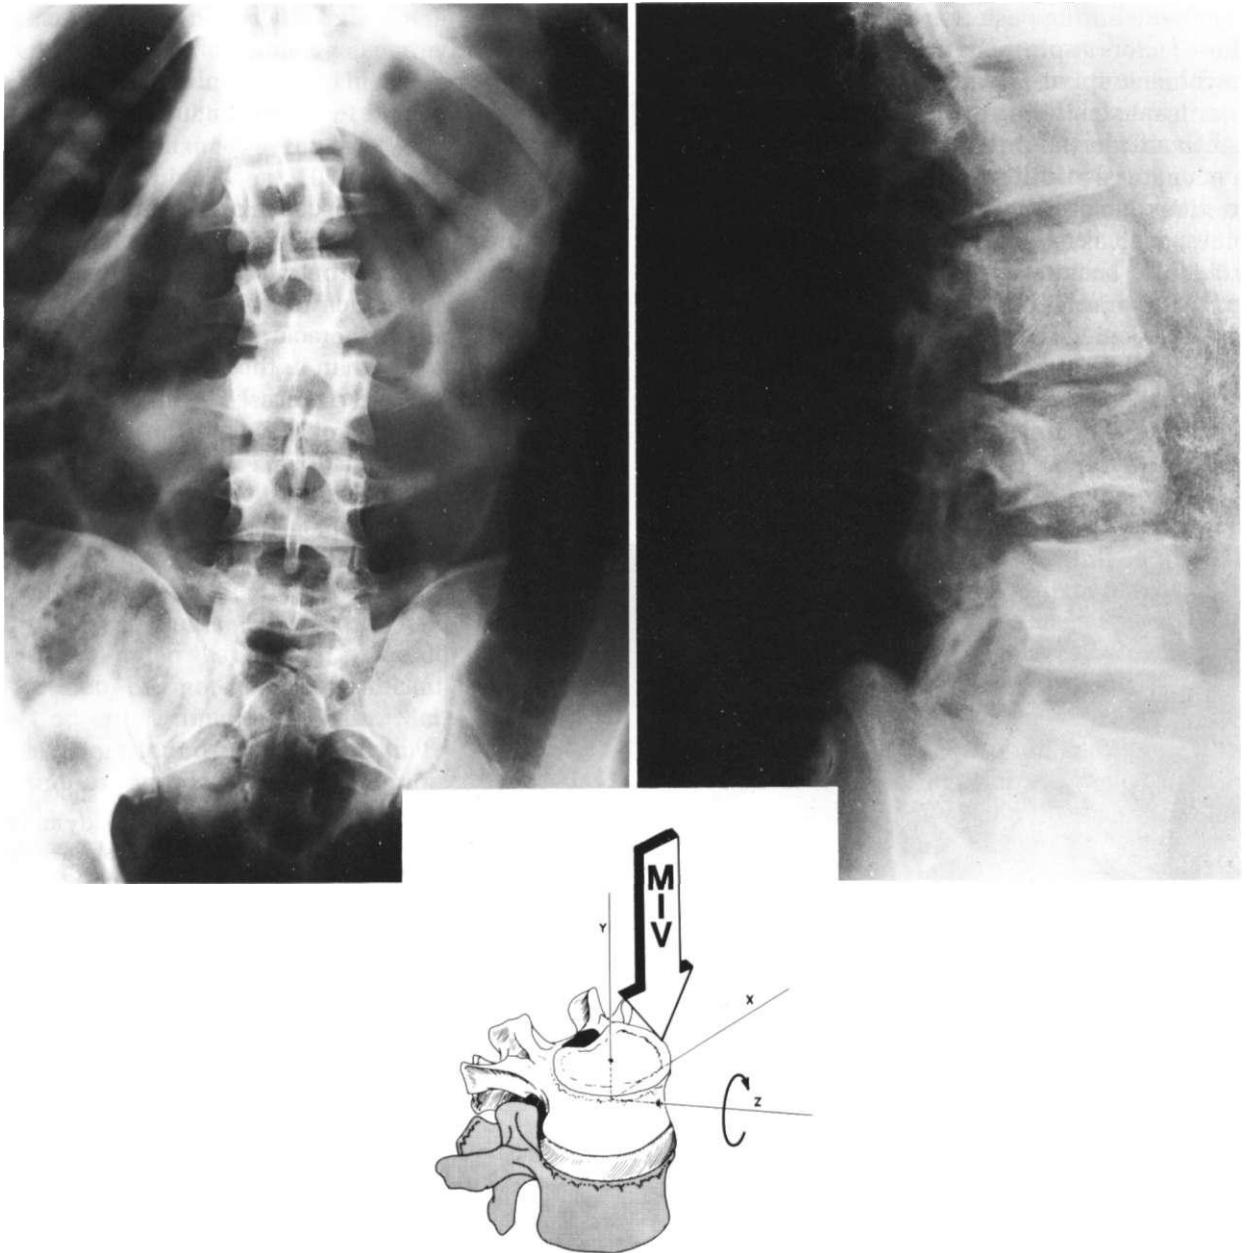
Radiographs of a patient who sustained a high-magnitude lateral wedge injury. There is asymmetrical compression of the left side of the third lumbar vertebra. There is slight compression of the pedicle and articular facet, indicating compressive loading. The right transverse process of L3 is fractured because of tensile loading on the opposite side. These factors show that the spine has been subjected to a left ($-z$ -axis) bending moment in the coronal plane. Just to the right of the base of the spinous process of L3 there is a displaced fracture of the lamina. This may be a shear fracture; in a beam subjected to bending, there is maximum shear stress around the neutral axis. The radiograph on the right (the lateral view) shows the vertebral end-plate compression fractures.
